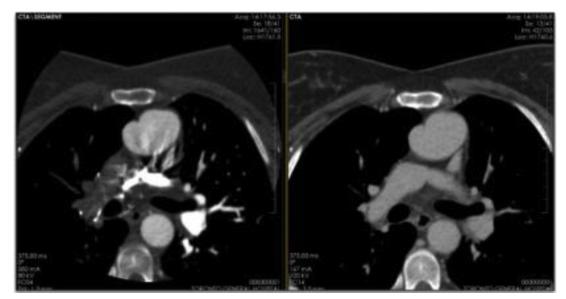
CT scan demonstrating intrapulmonary thrombus.
